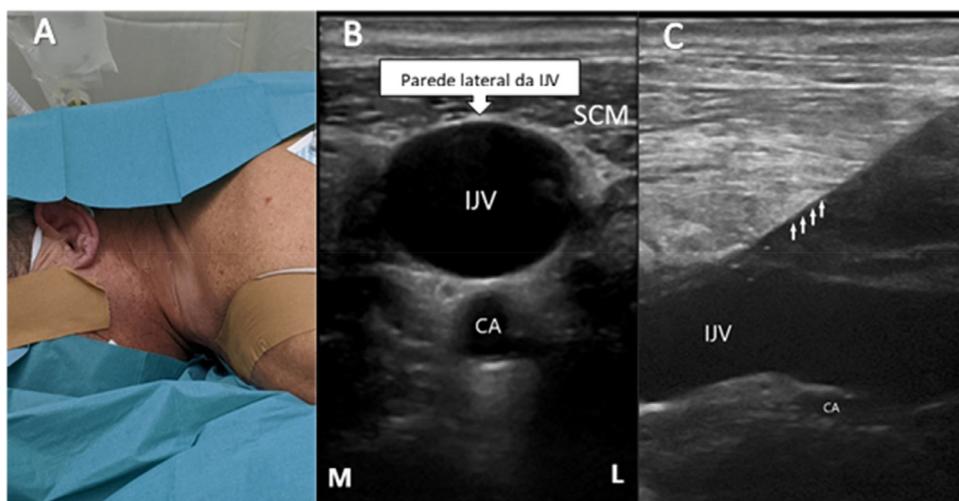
A, Positioning of the patient for CVC placement in the prone position; B, anatomical US landmarks of the out-of-plane approach; C, Direct ultrasound image of needle insertion during in-plane approach. CVC, Central Venous Catheter; SCM, Sternocleidomastoid Muscle; IJV, Internal Jugular Vein; CA, Carotid Artery; ↑↑↑↑, needle; M, Medial; L, Lateral.
